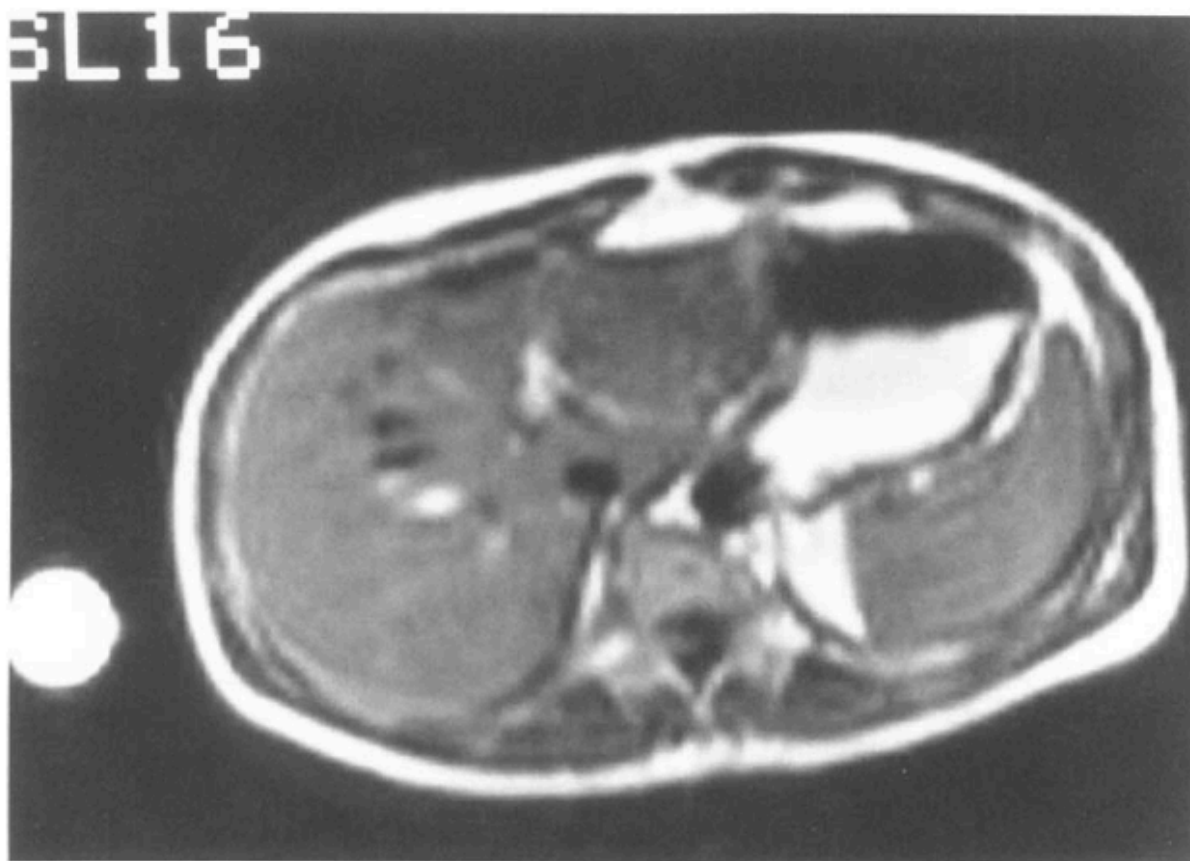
Contrast-enhanced gastric MRI of fundic lumen labeled with Gd-DOTA. The stomach was divided into gastric air and the gastric content. This figure is adapted from [81].
